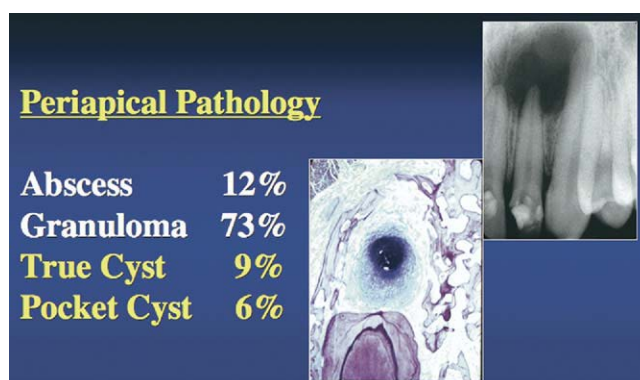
According to Nair (3, 4), 15% of all periapical radiolucencies are some type of cyst. From (5)
